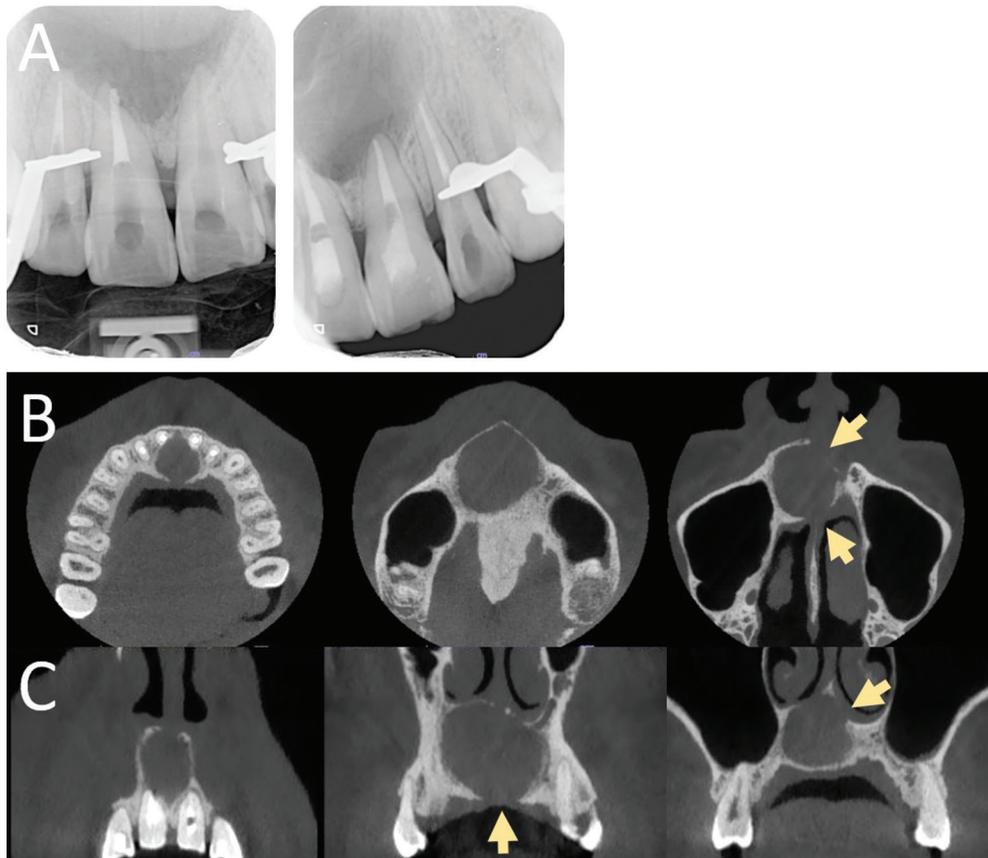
Radiography findings (A) Periapical radiographs show a well-defined unilocular radiolucent lesion at the midline of the maxillary region. There was root resorption at tooth 11. (B) From axial CBCT images, the arrows show labial and nasal floor perforation. (C) From coronal CBCT images, the arrows show palatal and nasal floor perforation.
